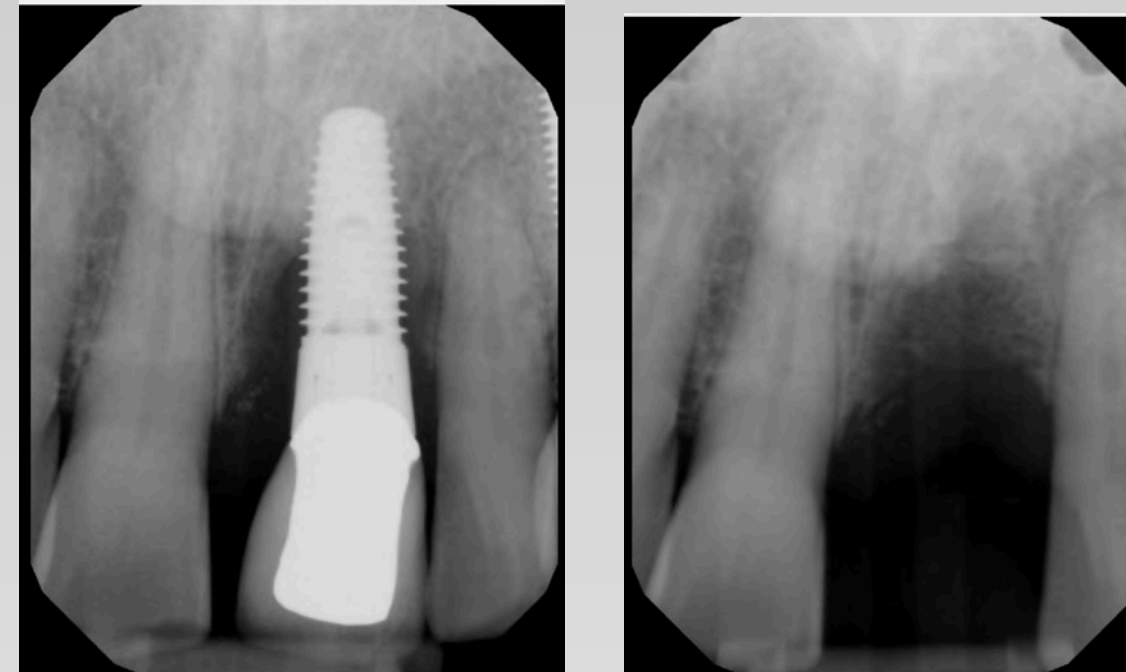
#9 implant with significant bone loss, the image on the right shows 3 months post-implant removal. This X-ray was also used to determine bridge restorability
